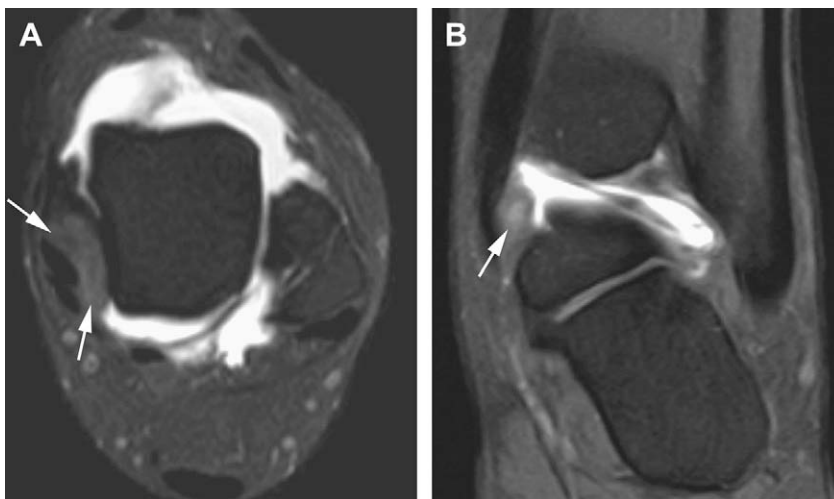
Posteromedial impingement syndrome. (A, B) Axial and coronal fat-suppressed T1-weighted MR arthrograms of the left ankle show hypertrophic fibrotic tissue in the posteromedial aspect of the ankle (arrows) behind the posterior tibiotalar ligament and deep to the posterior tibial tendon.
